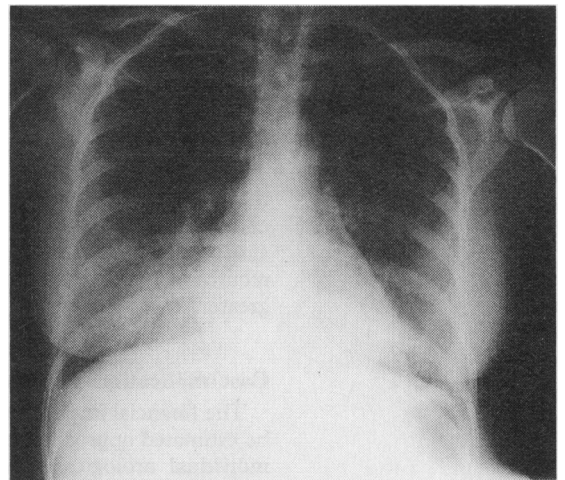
Chest radiograph taken during episode of acute breathlessness showing upper lobe blood diversion, alveolar shadowing, and septal lines. These signs confirm the diagnosis of acute pulmonary oedema
